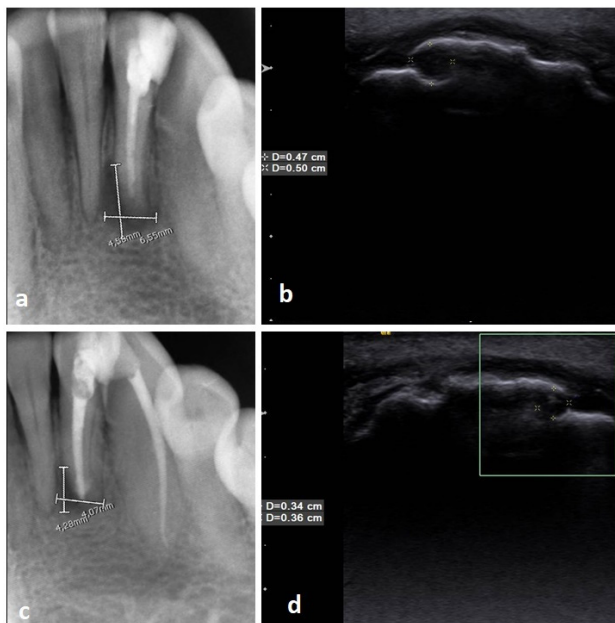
(a) Pre-treatment periapical radiography of a patient from group C. Representative maximum width and height measurement of a periapical lesion related to left mandibular lateral incisor. (b) Pre-treatment ultrasound image of the same periapical lesion shows width and depth measurements. (c) Post-treatment periapical radiography of the same patient, shows width and height measurements of the periapical lesion. (d) Post-treatment ultrasound image shows width and depth measurements of the periapical lesion suggesting reduction in lesion size
